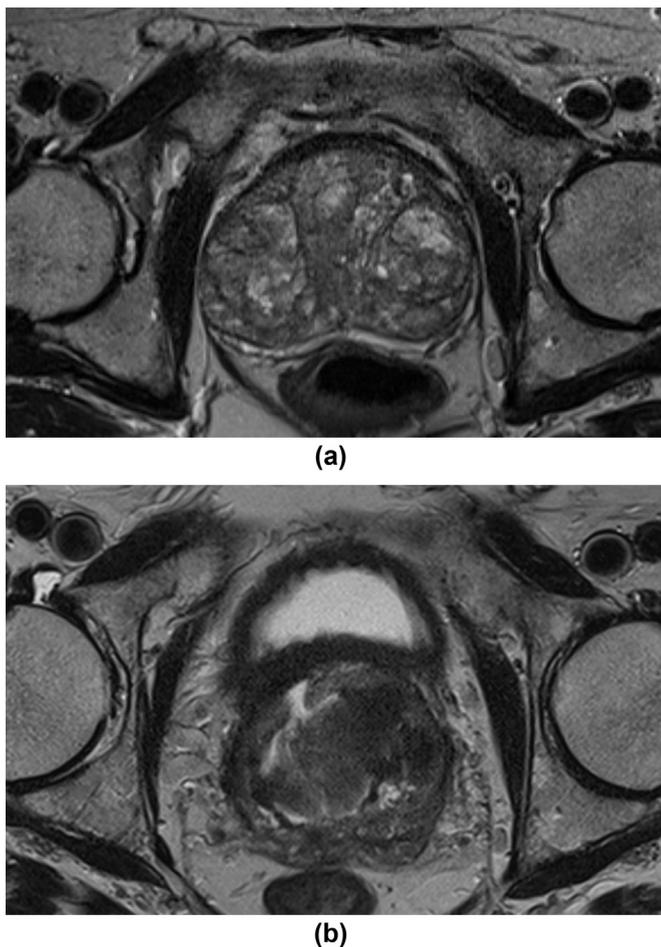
T2-weighted axial MRI images through the prostate gland. (a) Pre-PAE study demonstrates multiple T2 hyperintense areas consistent with adenomatous-dominant BPH. The measured prostate volume was 282 ml. (b) Post-PAE study demonstrates a marked loss of T2 signal in central gland areas in keeping with necrosis, and measured prostate volume reduced to 110 ml.
